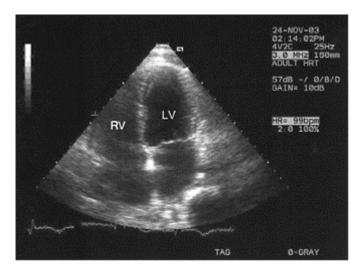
Right ventricular infarction. Apical four-chamber view. Right ventricular dilation in acute phase of right ventricular infarction. LV: left ventricle; RV: right ventricle.
